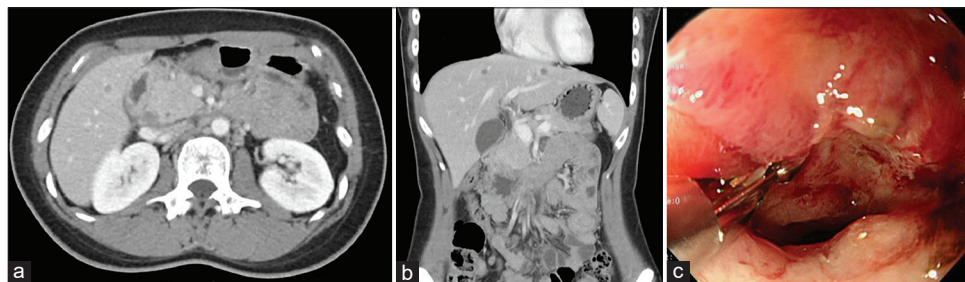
Initial imaging of metastatic duodenal adenocarcinoma. (a) Computed tomography (CT) demonstrating a primary duodenal mass. (b) CT showing liver metastases. (c) Endoscopy revealing an ulcerative tumor in the second portion of the duodenum
